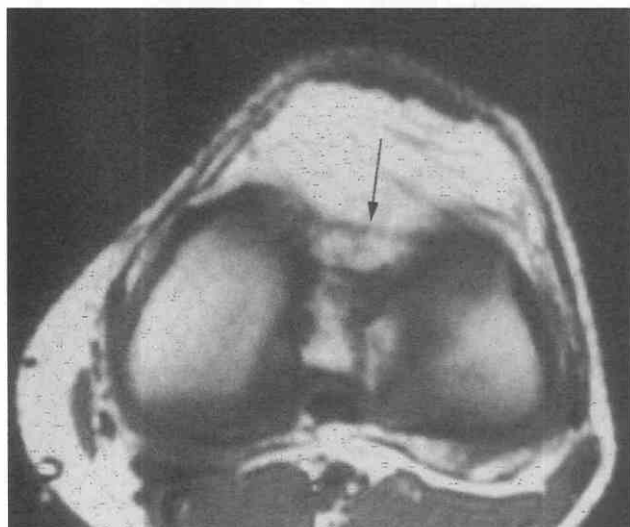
Transverse ligament. Axial T1-weighted image shows the transverse ligament extending from the medial joint compartment to the lateral joint compartment (arrow).
